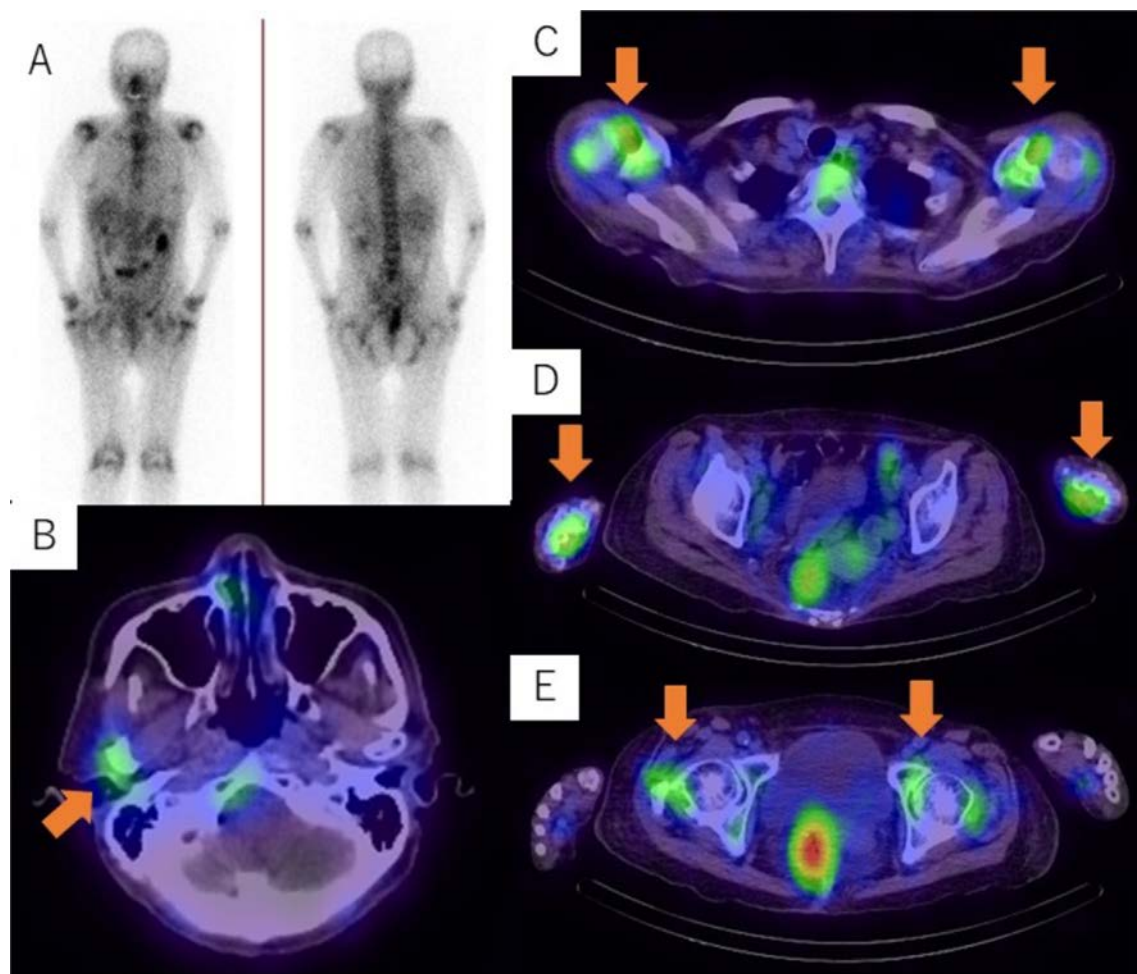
(A) Gallium scintigraphy showing uptake in major joints throughout the body. (B) Focal uptake in the right temporomandibular joint (arrow). (C) Uptake in bilateral shoulder joints (arrows). (D) Uptake in bilateral wrist joints (arrows). (E) Uptake in bilateral hip joints (arrows).
